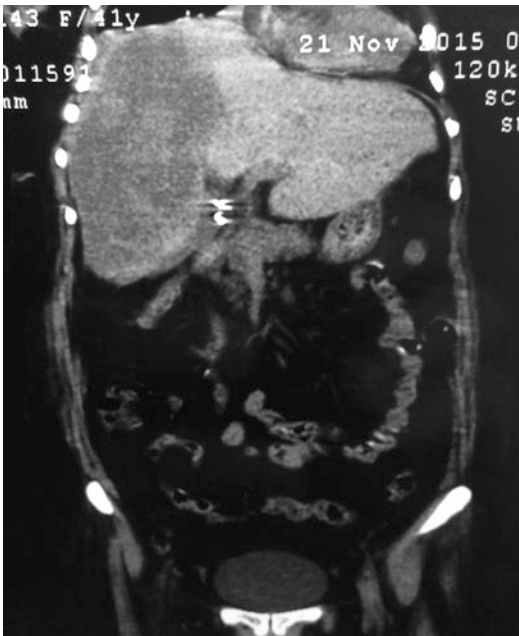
Ischemia of right lobe of liver seen on CT
